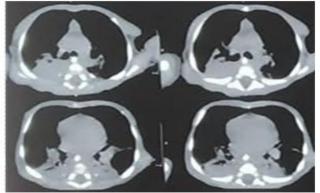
HRCT Chest of case 1-showing confluent areas of consolidation in dependent upper and lower lobes of bilateral lungs with discrete areas of Ground-Glass Opacities noted adjacent to the areas of consolidation
